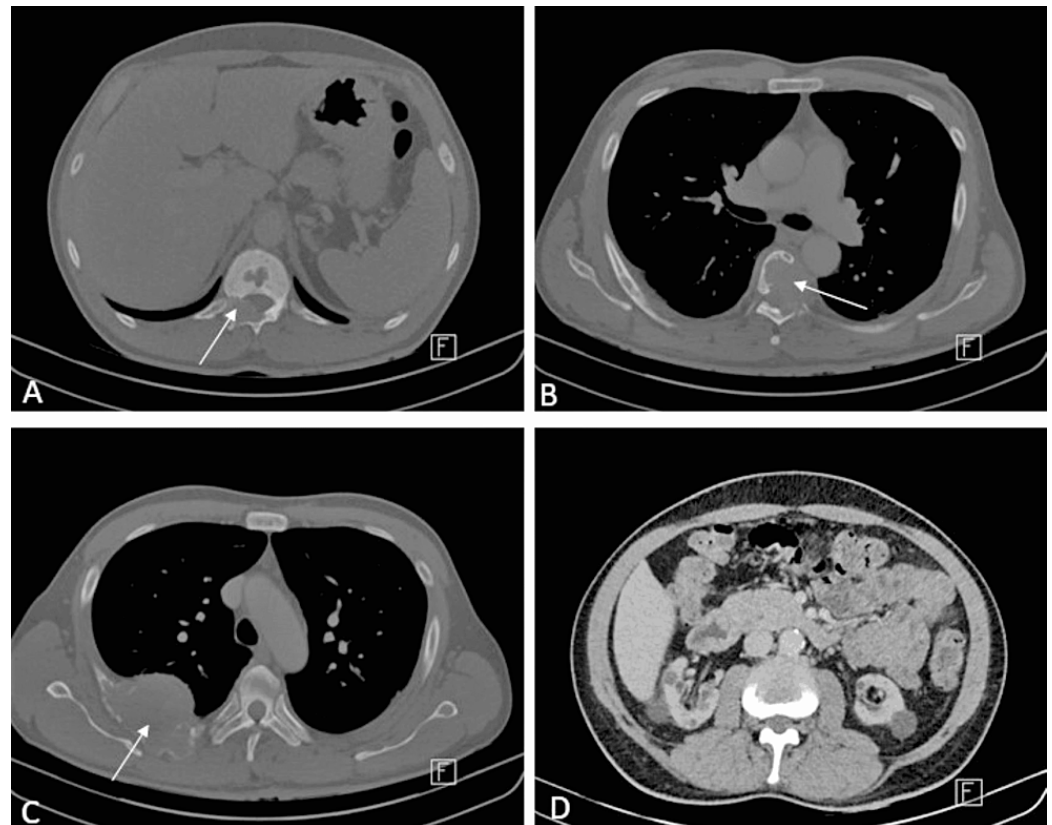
Axial CT scan of the chest and abdomen. Expansile lytic lesion at T12 vertebra (A) and T6 vertebra extending to the right pedicle and lamina (B). Large destructive expansile lytic lesion involving the right posterior fifth rib (c). The kidneys are atrophied with multiple bilateral simple cysts (D).
